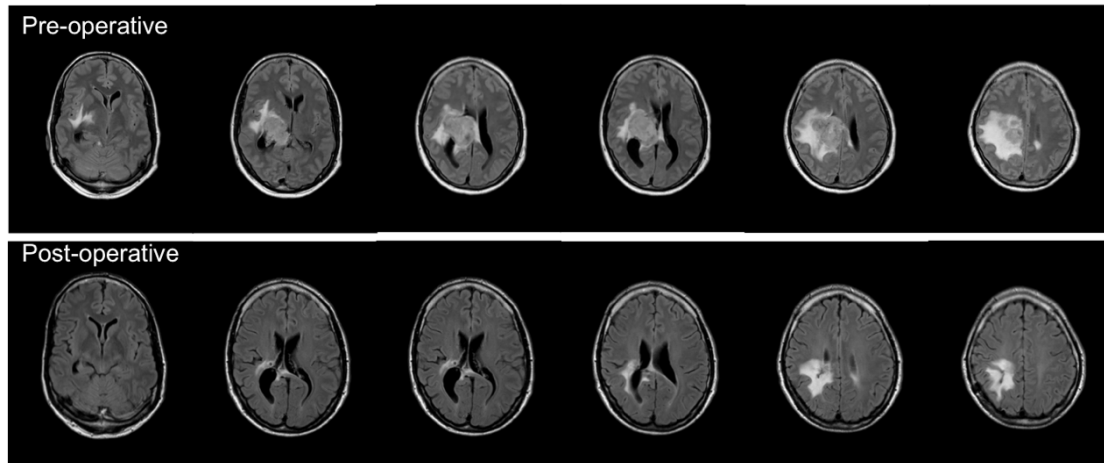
MRI scans with T2-weighted images with fluid attenuated inversion recovery (Flair) in axial plane. The upper row represents pre-operative images showing a circumscribed right intraventricular lesion with dimensions 5x4x4 centimeters (with T1 enhancement after gadolinium administration; not shown). The lesion is accompanied by a large area of subcortical edema extending cranially from the tumor as well as some mesiotemporal edema. The bottom row represents post-operative images (6 months prior to the current study). These images show residual right parietal hyper intensities (gliosis) and a small area of postoperative cortical changes located posteriorly in the parietal lobe. Some residual T1 gadolinium enhancement of the lateral ventricle wall was seen (unchanged compared to previous postoperative MRI scans; images not shown). Note that images are in radiological orientation (left side of the image is the right side of the brain).
